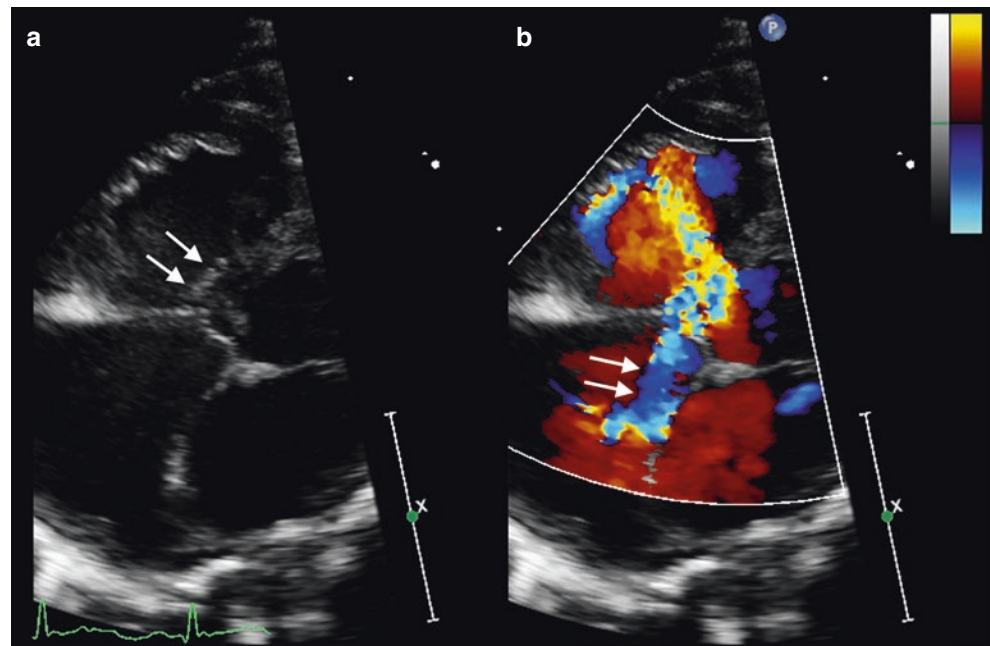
Large perimembranous VSD (*arrow*) visualized in the subcostal coronal view (a) depicting its proximity to the aortic valve (AO). Colour Doppler displays LR-shunting across the VSD (b). *PA* pulmonary artery, *RV* right ventricle
